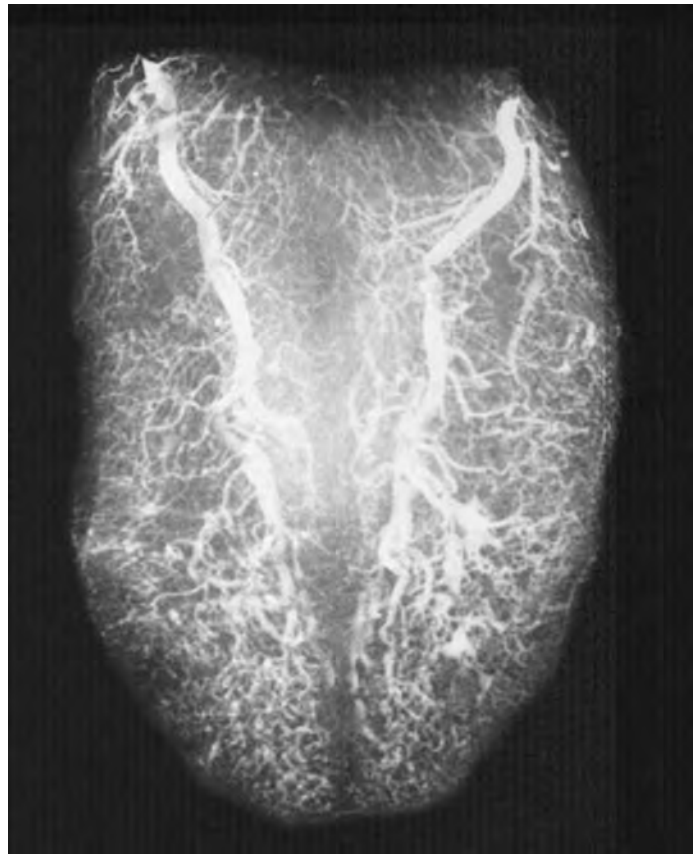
Radiograph of the tongue; note the almost avascular midline. (From Houseman ND, Taylor GI, Pan WR. *The angiosomes of the head and neck: anatomic study and clinical applications*. Plast Reconstr Surg. 2000;105:2287.)
